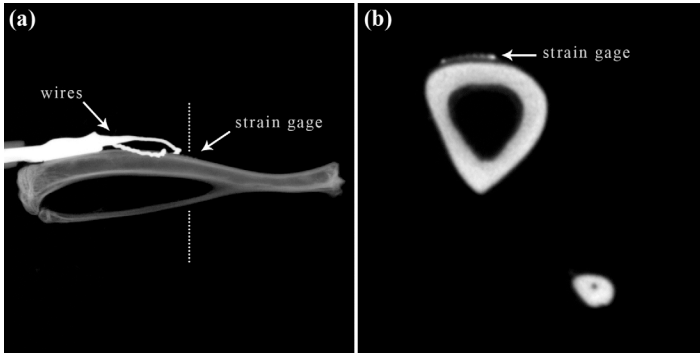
(a) Side-view of a μ CT scan of a tibia with a strain gage placed at Zone 2 and connecting wires. (b) Profile view along dotted line showing the strain gage linkage to the bone follows the contour of bone surface.
